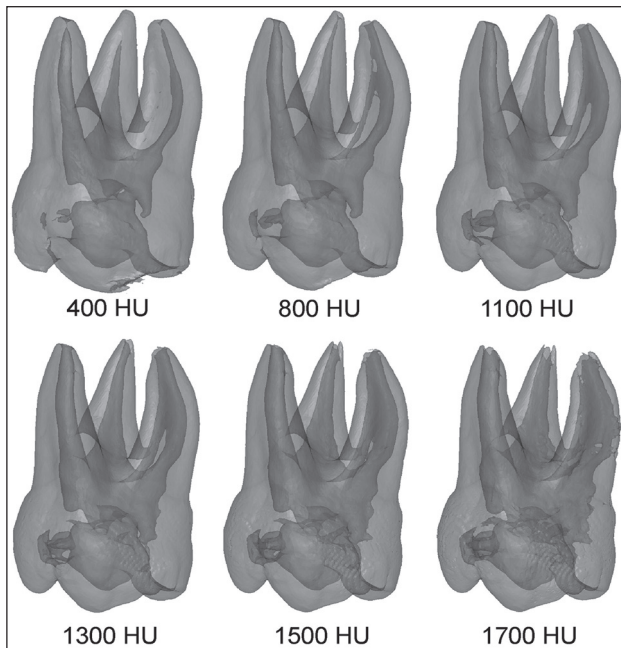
Three-dimensional reconstruction of the hard tissues and root canal system of the upper molar based on cone beam computed tomography data according to different threshold values, sagittal view.
